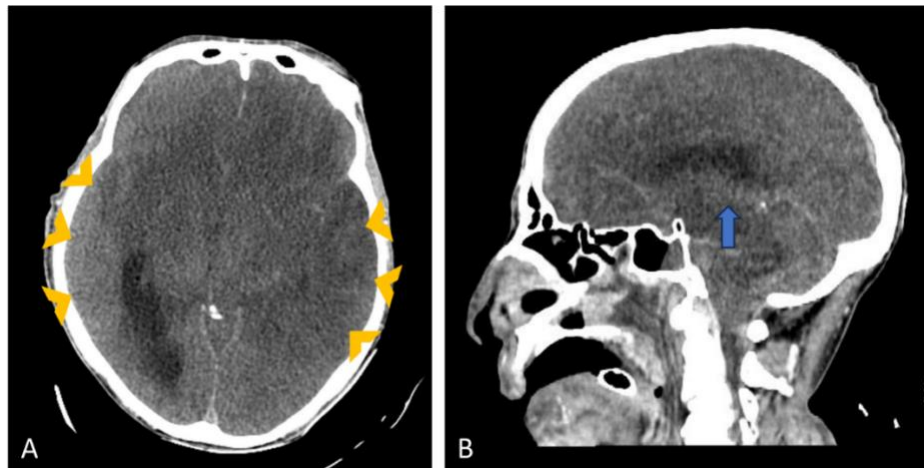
CT angiographic findings of cerebral circulatory arrest.
